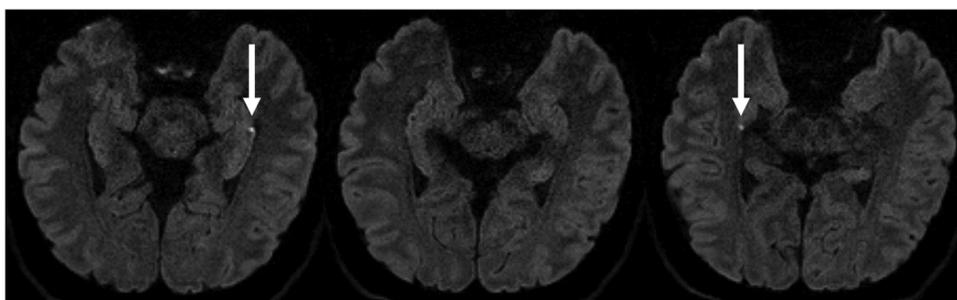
Hippocampal MRI in TGA patients.
